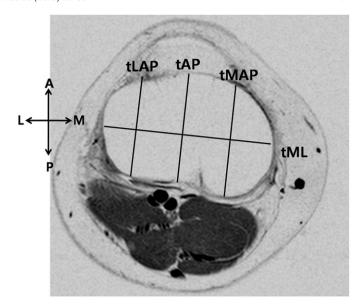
Axial MRI image of the proximal tibia showing the mediolateral length of tibia (tML), the anteroposterior length of tibia (tAP), the medial anteroposterior length (tMAP), the lateral anteroposterior length (tLAP).
